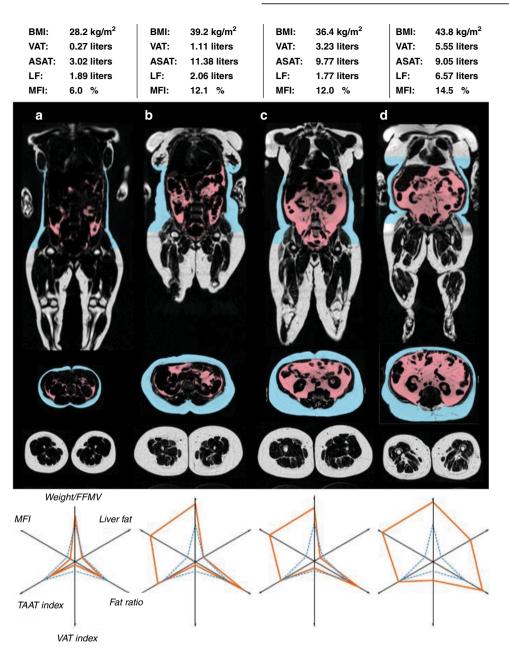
Body composition in four different individuals with achondroplasia. The coronal and abdominal axial magnetic resonance images show visceral adipose tissue (VAT) in red and abdominal subcutaneous adipose tissue (ASAT) in blue. Below, axial images of the thighs. At the bottom, the orange lines show the individual body composition profiles compared with reference values (blue dashed lines) based on median of the metabolic disease–free UK Biobank reference population (n = 2927). Individuals A, B, and C had low VAT, while individual B, C, and D had moderately increased ASAT. Increased liver fat was seen in individual D. Individuals B, C, and D had increased muscle fat infiltration (MFI). All four individuals had decreased fat-free muscle volume (FFMV), as reflected by the high weight/FFMV ratio. *ASAT* abdominal subcutaneous adipose tissue, *BMI* body mass index, *FFMV* fat-free muscle volume, *LF* liver fat, *MFI* muscle fat infiltration, *TAAT* total abdominal adipose tissue (VAT + ASAT), *VAT* visceral adipose tissue.
